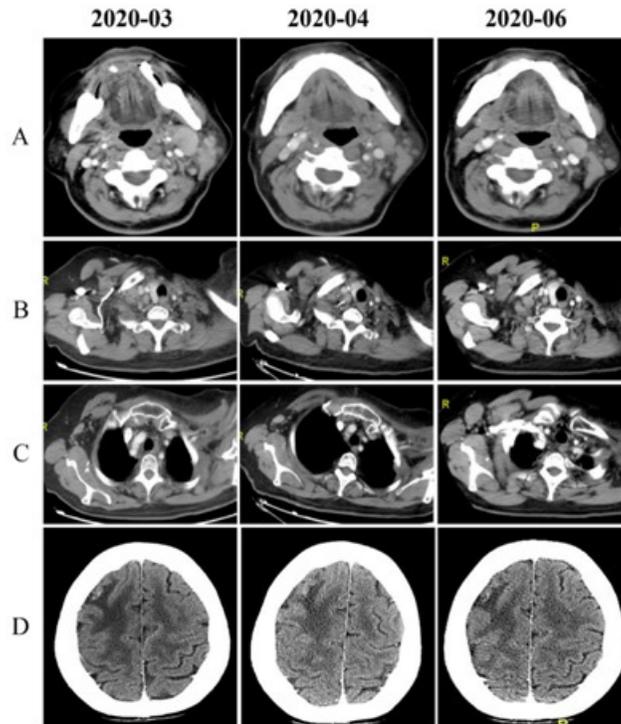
Enhanced CT scan before and after the 2 and 4 cycles of the treatment of vinorelbine and oxaliplatin. The right supraclavicular lymph node (B) and the right axillary lymph node (C) were stable after 2 cycles of treatment but significantly enlarged after another 2 cycles. The left Cervical lymph node (A) and the metastatic brain lesion (D) were stable. CT, computed tomography.
